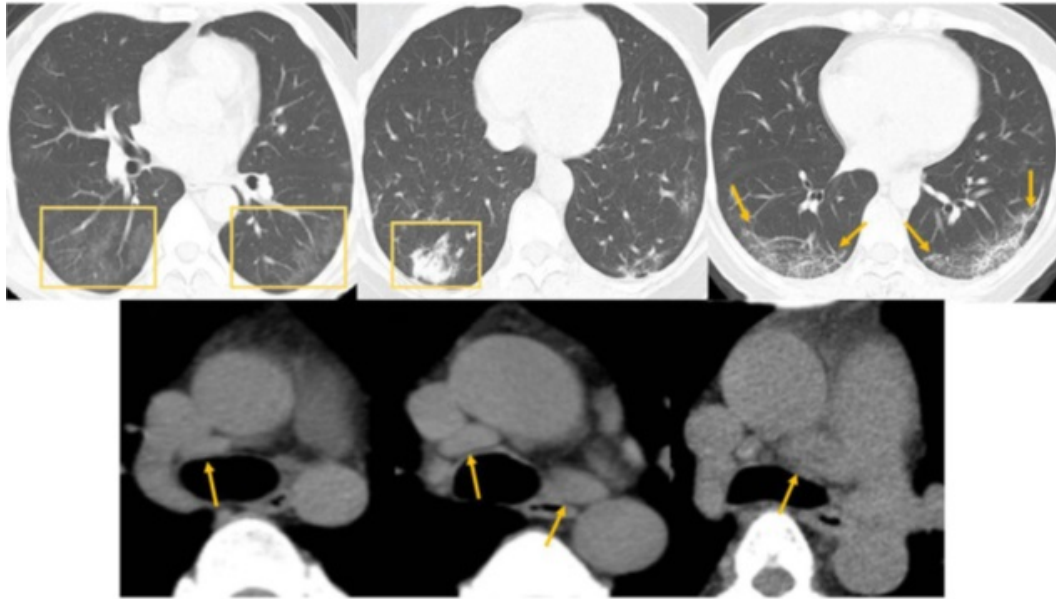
Regression in thoracic CT findings in patients preparing for discharge.
